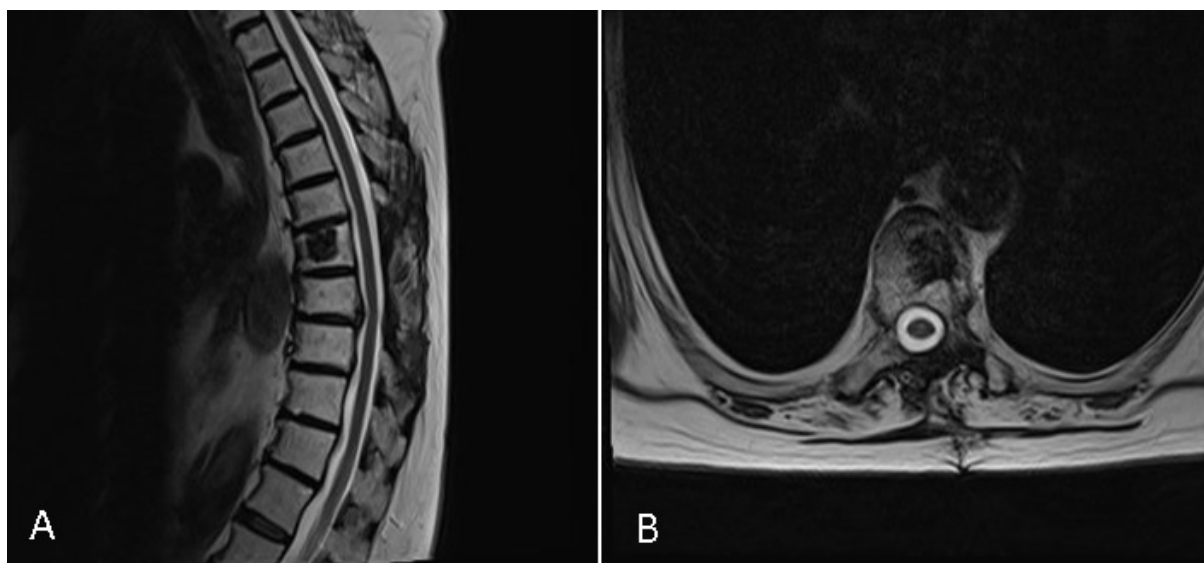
(A) T2W sagittal and (B) T2W axial control MRI sections at the postoperative 15th month, showing the mass was completely excised and no local recurrence was seen.
